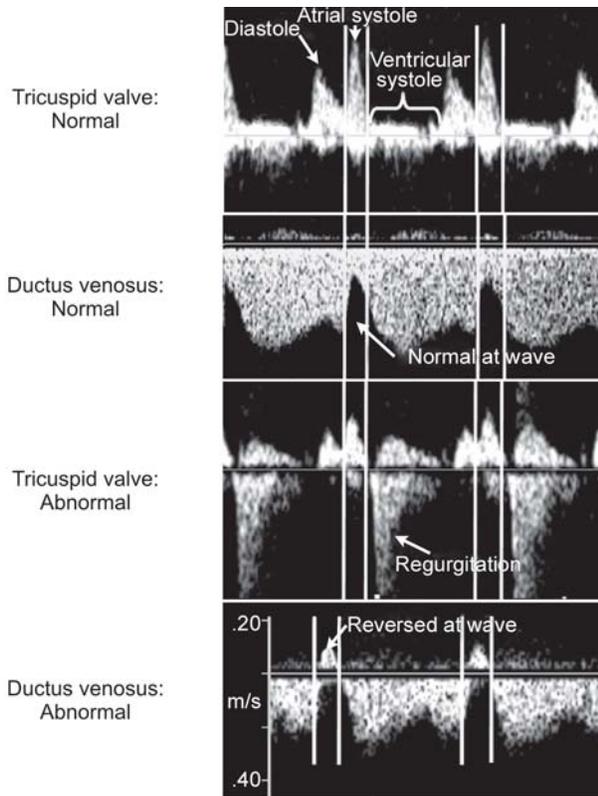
Temporal relationship of pulsed Doppler waveforms across the TCV and the DV: normal and abnormal
